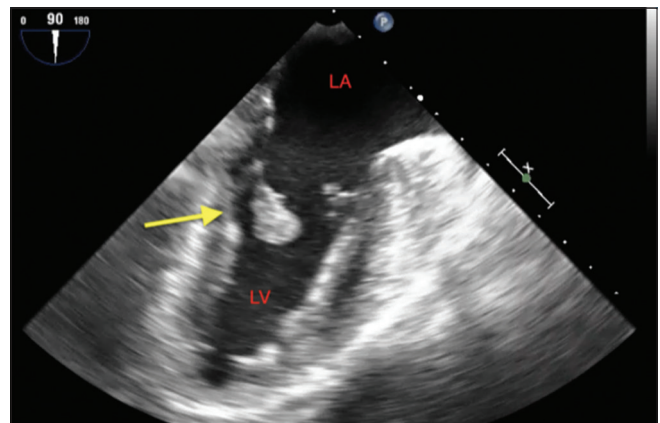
Transesophageal echocardiography. Midesophageal two-chamber view with myxoma (arrow). LA: Left Atrium, LV: Left Ventricle, Ao: Aorta
